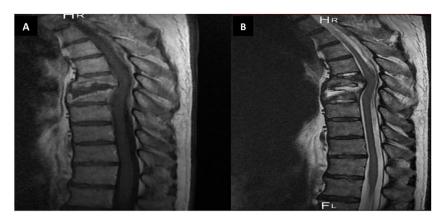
Sagittal T1-weighted after injection of Gadolinium (A), T2-weighted (B) magnetic resonance imaging (MRI) sequences of the spine show an infectious spondylodiscitis at tbl6 tbl7 level with an anterior and a posterior tbl6 tbl7 epiduritis, complicated by spinal cord compression.
